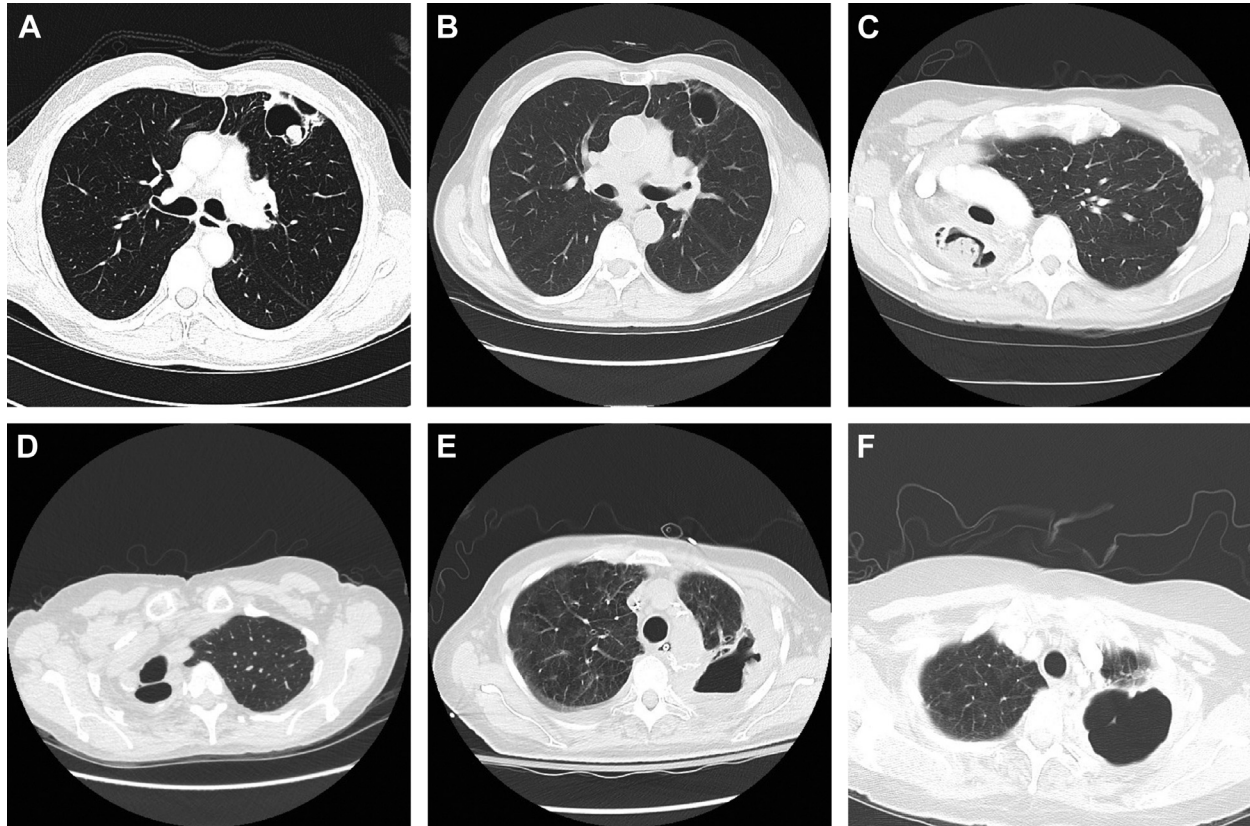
(A) Chest computed tomography (CT) image of symptomatic intracavitary aspergilloma in the lingula (case 2). (B) Chest CT image of empty cavity in a now-asymptomatic patient (case 2) 26 months after bronchoscopic aspergilloma removal. (C) Chest CT image of large, symptomatic right upper lobe aspergilloma (case 3). (D) Chest CT image of empty right upper lobe cavity in an asymptomatic patient (case 3) 24 months after bronchoscopic aspergilloma removal. (E) Chest CT image of the chest of symptomatic intracavitary aspergilloma in left upper lobe (case 4). (F) Chest CT image of the cavity 3 months after second bronchoscopic aspergilloma removal procedure (involving rigid bronchoscopy) in case 4; there has been minor improvement in cavity wall thickness with incomplete aspergilloma resolution.
